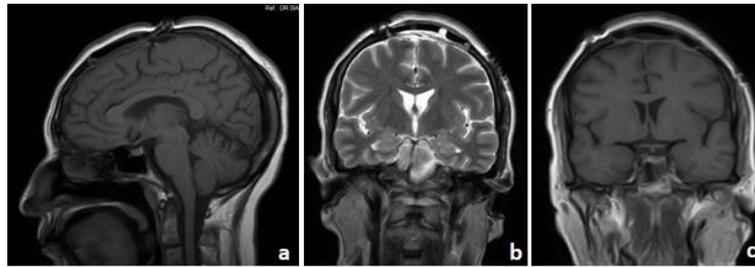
Postoperative cerebral MRI. a Sagittal T1-weighted image, b Coronal T2-weighted image, and c Coronal T1-weighted with contrast image shows complete resection of the tumor.
